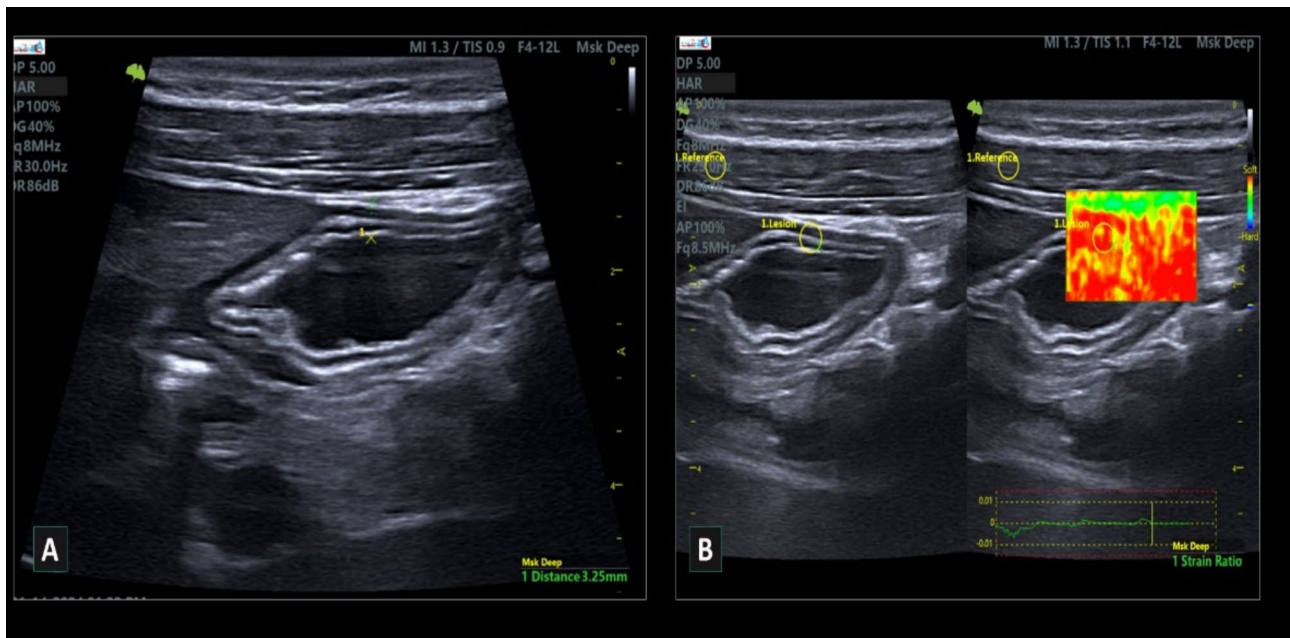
(A): B-mode sonogram for calculating anterior gastric wall (antral wall thickness [AWT]=3.25 mm) and (B): Elastogram in color coding for which the inner circle region of interest (ROI) in the colored box (Lesion) represents the antral gastric wall electrographic value, and the outer circle (Reference) represents the normal neighboring structure. The strain elastography ratio was automatically calculated using a device that divided the strain value of the inner box of the antral wall by the strain value of the normal surrounding structure
